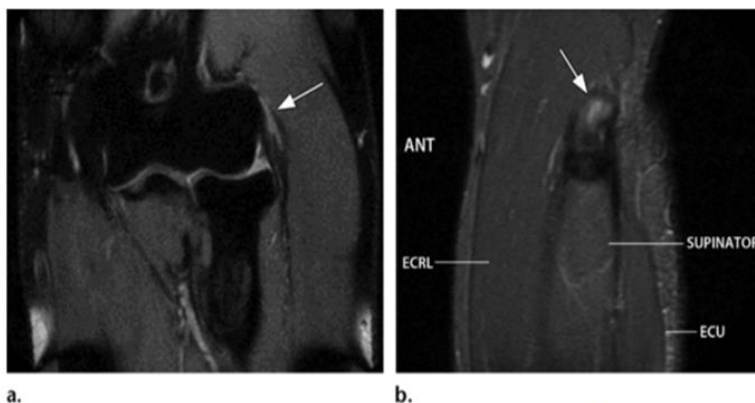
Moderate lateral epicondylitis. (a) Proton density-weighted fat-saturated MR image obtained in a 60-year-old man depicts a region of slightly increased signal intensity due to fluid accumulation within the superficial fibers of the common extensor tendon, a finding suggestive of a small partial-thickness tear (arrow). (b) Sagittal STIR MR image shows a central region with the signal intensity of fluid in the proximal common extensor fibers, with a surrounding rim of intermediate signal intensity (arrow), findings consistent with a partial-thickness tear and tendinosis. ANT = anterior, ECRL = extensor carpi radialis longus, ECU = extensor carpi ulnaris.
